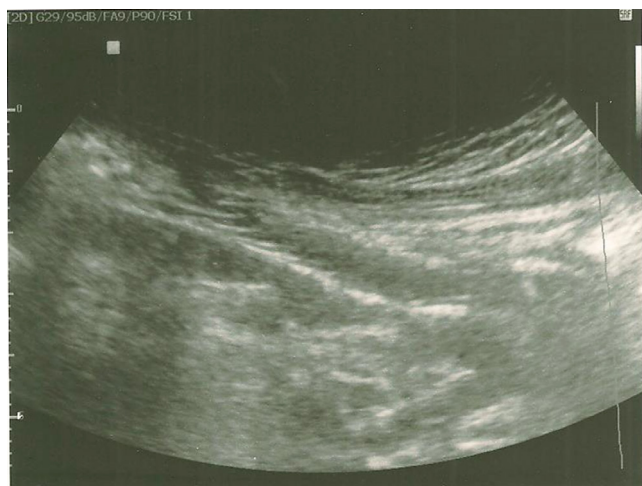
Pelvis ultrasound. The arrow indicates stents implanted into the right common iliac artery
